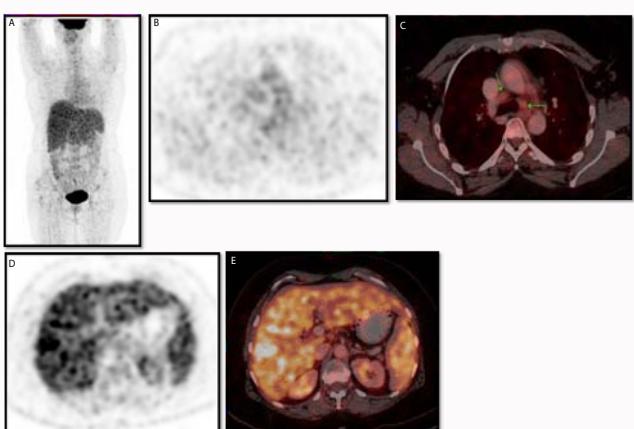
18F FDG PET/CT Whole body images (MIP Figure 2A) demonstrate moderate grade activity in mediastinal nodes (dedicated PET scan transaxial image Figure 2B and fused PET-CT transaxial Figure 2C). High grade heterogeneous FDG activity in entire liver and spleen (dedicated PET scan transaxial image Figure 2D and fused PET-CT transaxial Figure 2E).
